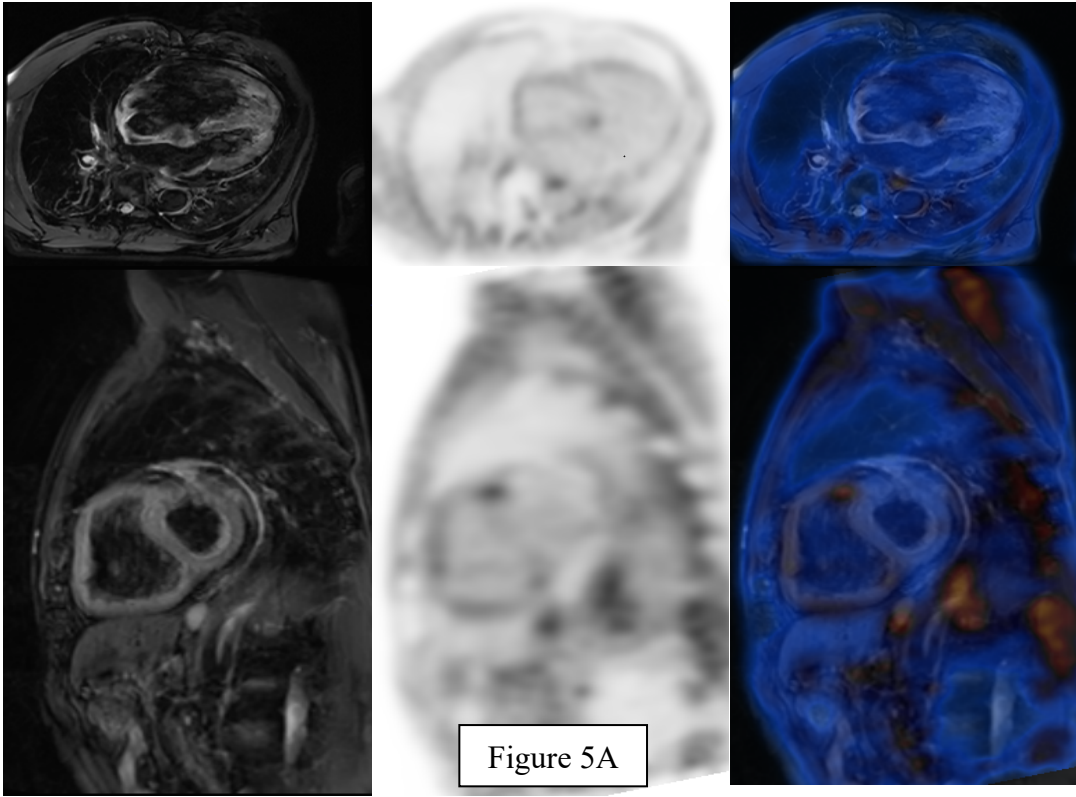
⁶⁸Ga-FAPI and FDG PET/MR images of a patient with heart failure and extensive fibrosis.
